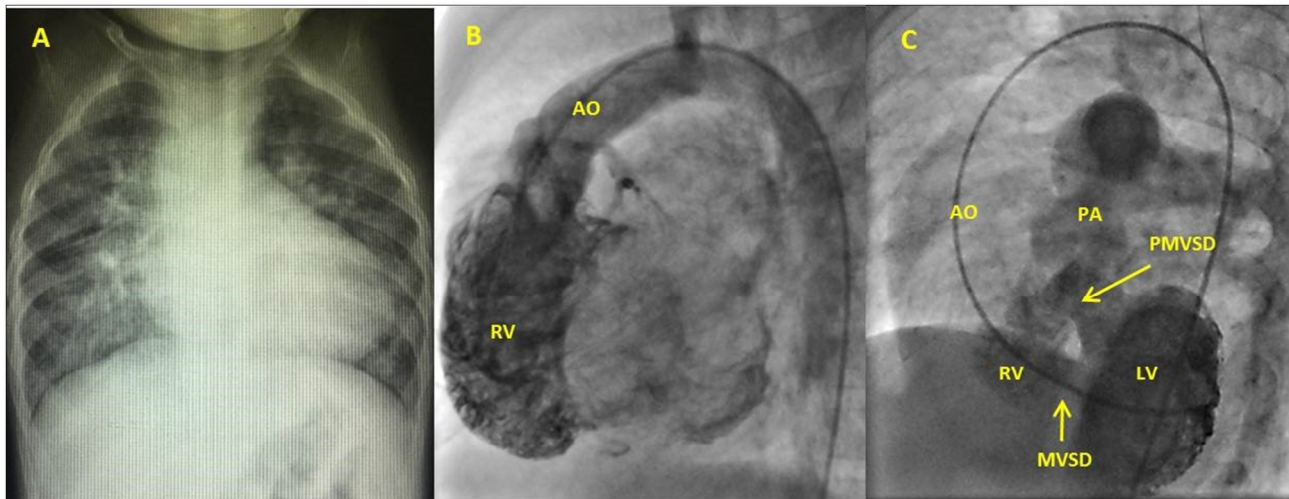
The Chest X-ray (A) and angiography (B and C) before surgery.
